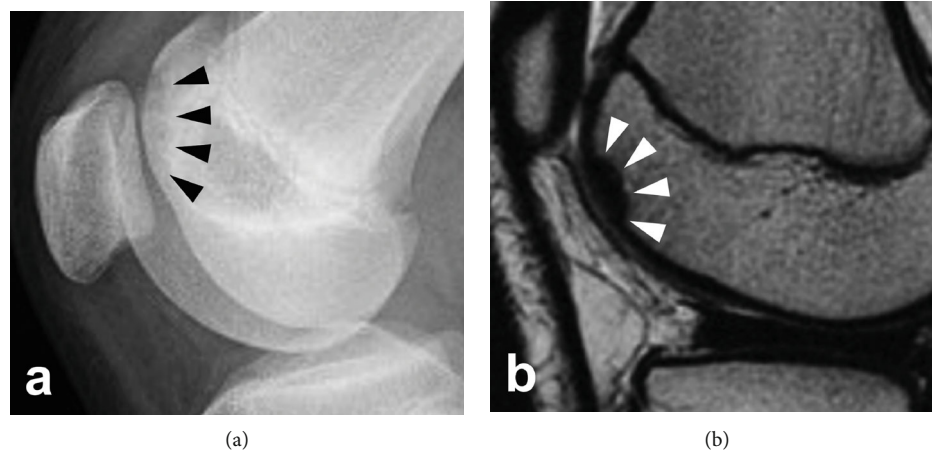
(a) Lateral view radiograph of the right knee showing Brückl's stage II OCD lesion in the lateral facet of the femoral trochlea. (b) T2-weighted MRI sagittal image of the right knee indicating Nelson's stage I lesion in the lateral facet of the femoral trochlea.
